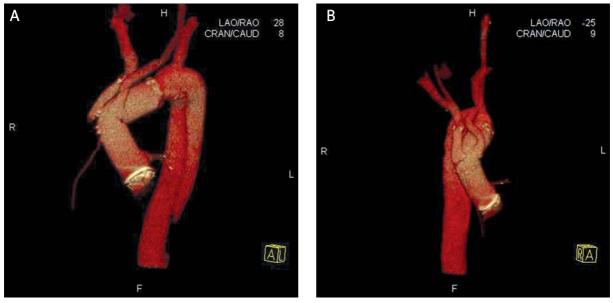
Computed tomography scans showing results of the first step of treatment – Bentall procedure with aortic graft valve implantation, by-pass to the right coronary artery, transposition of the brachiocephalic trunk and left common carotid artery to the aortic prosthesis with the use of Dacron prostheses *Ryc. 3. Zdjęcia tomografii komputerowej prezentują stan po pierwszym etapie leczenia – implantacja zastawkowego graftu aortalnego metodą Bentalla, by-pass do prawej tętnicy wieńcowej oraz zespolenie pnia ramienno-głowowego i tętnicy szyjnej wspólnej z protezą łuku aorty za pomocą dakronowych protez naczyniowych*
